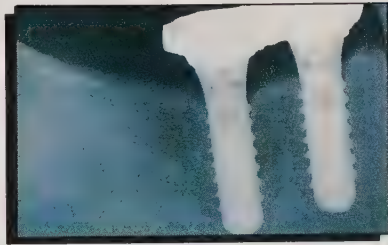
Radiograph showing framework try-in for two-unit PFM bridge on ITI solid screw implants.
